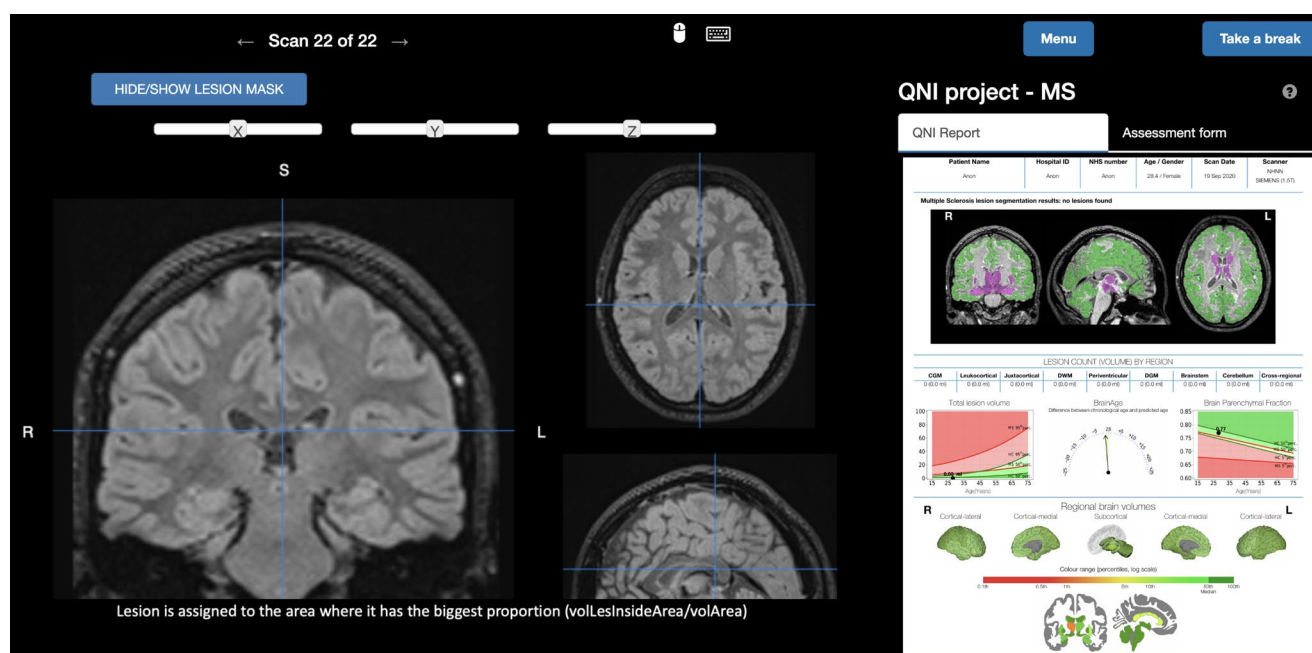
Screenshot of the credibility study website portraying a scrollable MRI scan in three planes (left) and the Qreport (right)
